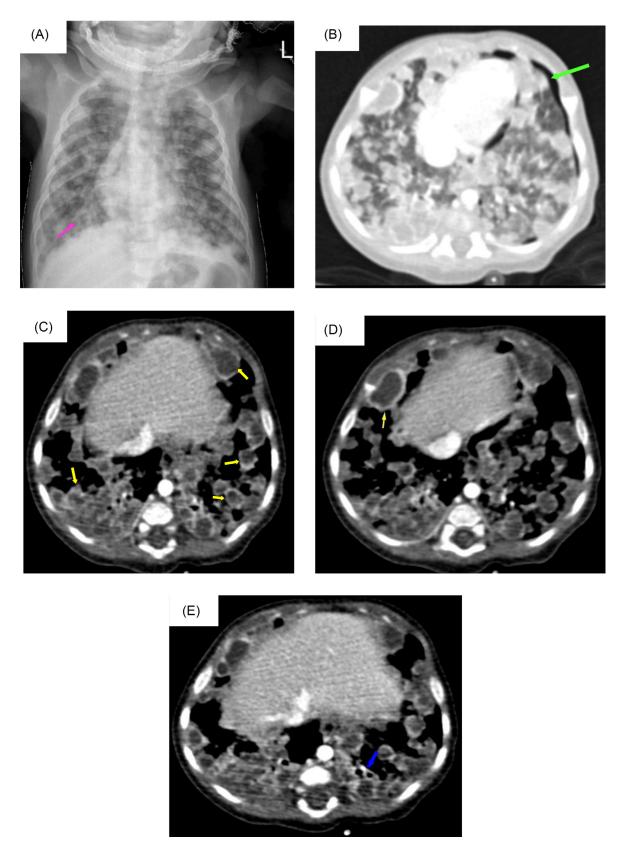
(A) Chest radiograph taken at admission shows multi-focal bilateral randomly distributed nodular air space opacities, some having central cavitation (pink arrow). (B) Chest CT, axial lung window showing multiple nodular opacities and left side pneumothorax (green arrow). (G-E) Chest CT, Axial soft tissue window images showing multiple, predominantly peripheral ring enhancing collections (yellow arrow) and feeding vessel sign (blue arrow).
